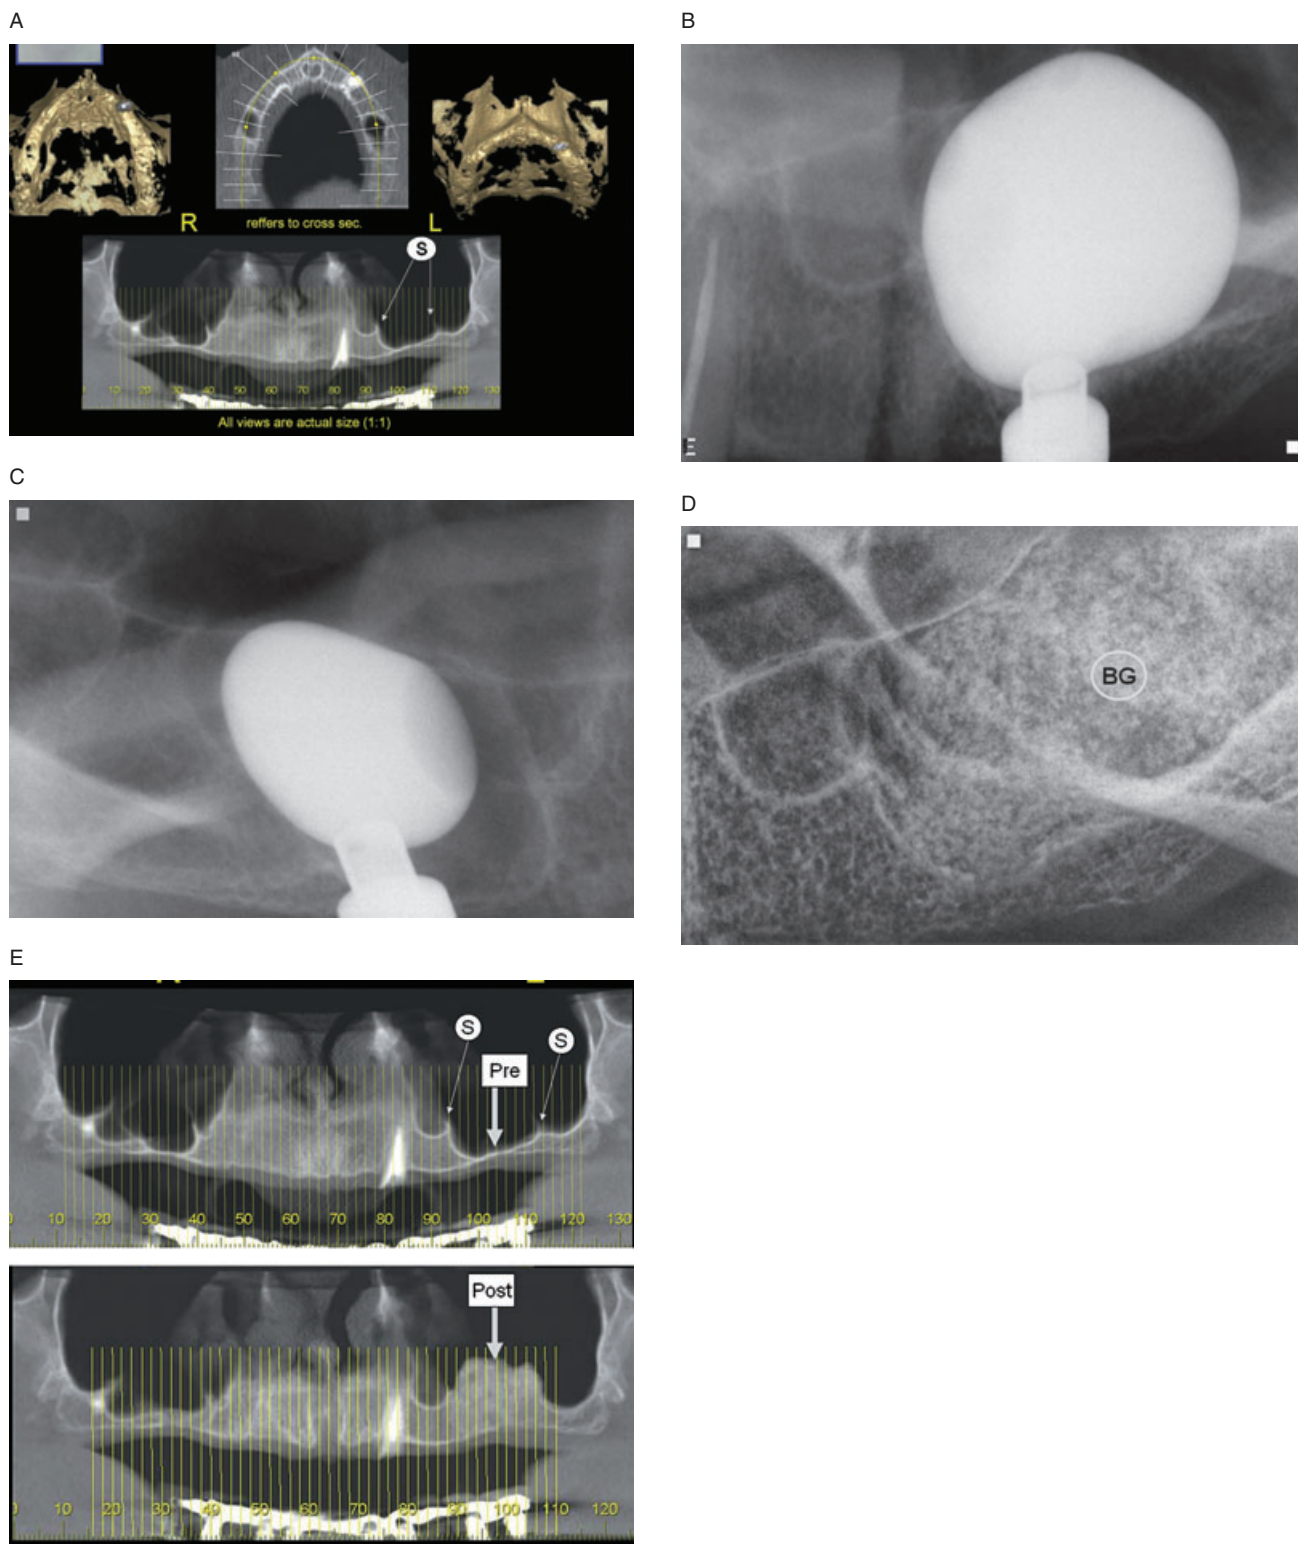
MIAMBE performed in complex pathology (eggshell atrophic maxillary bone and maxillary sinus with 2 septa). *A*, Pre-procedural CT: note bone height is 1 mm and double septum (s). *B*, Medial MIAMBE. *C*, Lateral MIAMBE. *D*, After bone grafting (BG). *E*, Bone height 6 months later.
